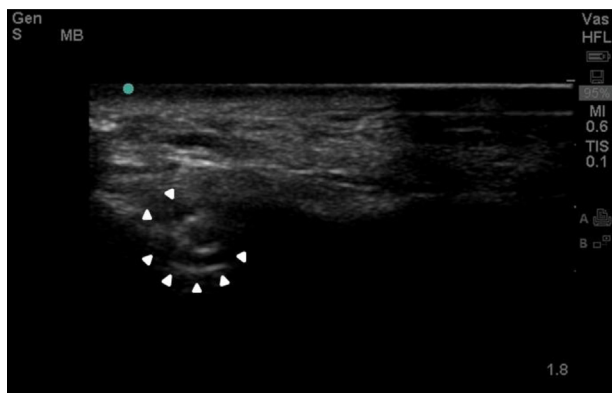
Post-injection ultrasound image showing the spread of the agent around the nerve (doughnut sign).
